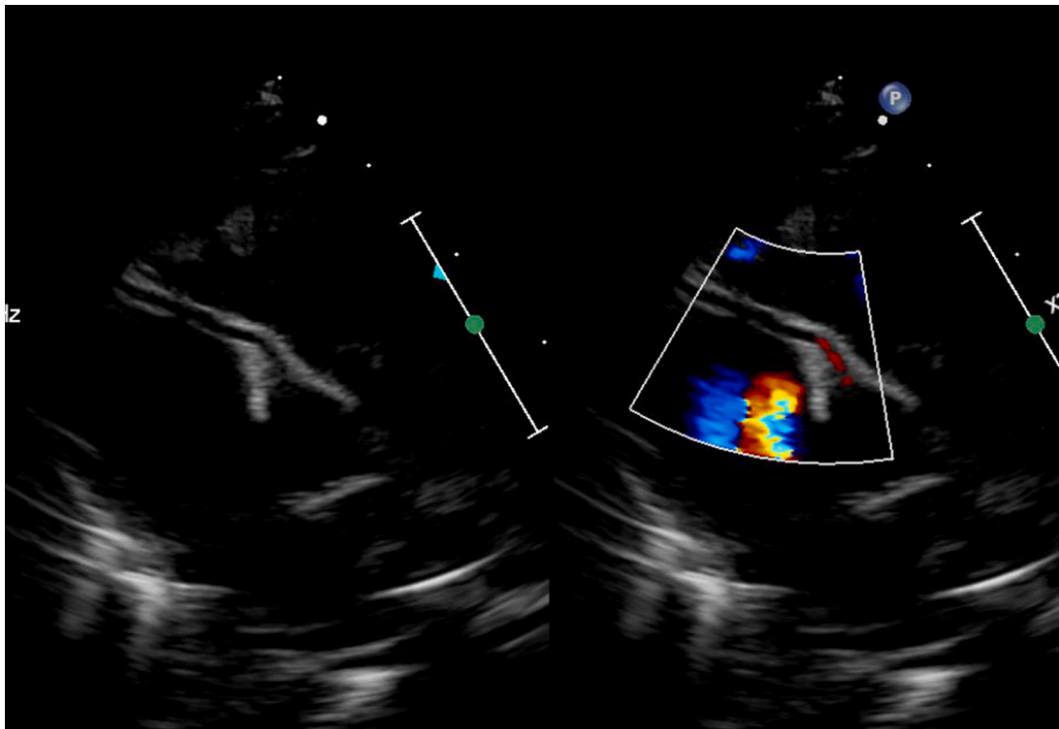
Normal origin of the right coronary artery. In this picture the right coronary artery can be seen arising from the right sinus of Valsalva at the 11 o'clock position. Color Doppler imaging shows a red Doppler color pattern within the right coronary artery indicating appropriate flow from the aorta into the right coronary artery.
